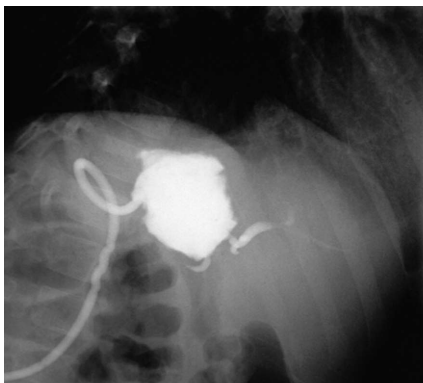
A 3-year-old boy developed a biloma 12-mo after receiving left lateral segment from a live-donor. He had a persistent bile leak and segmental bile duct dilatation on abdominal computed tomography scan imaging. A fistulography was performed by injecting contrast through the pigtail catheter, and an excluded bile duct was evidenced.
